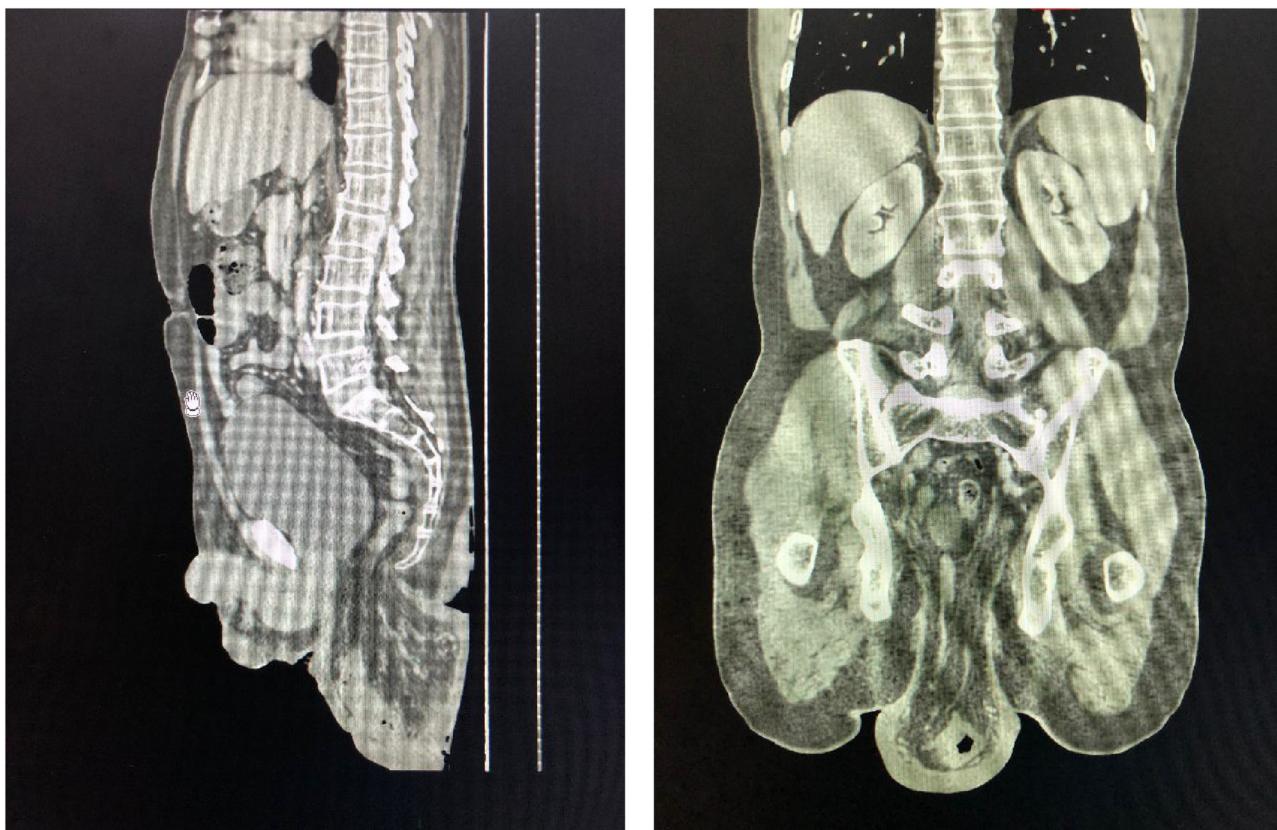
CT scanner image of full-thickness massive rectal prolapse.
